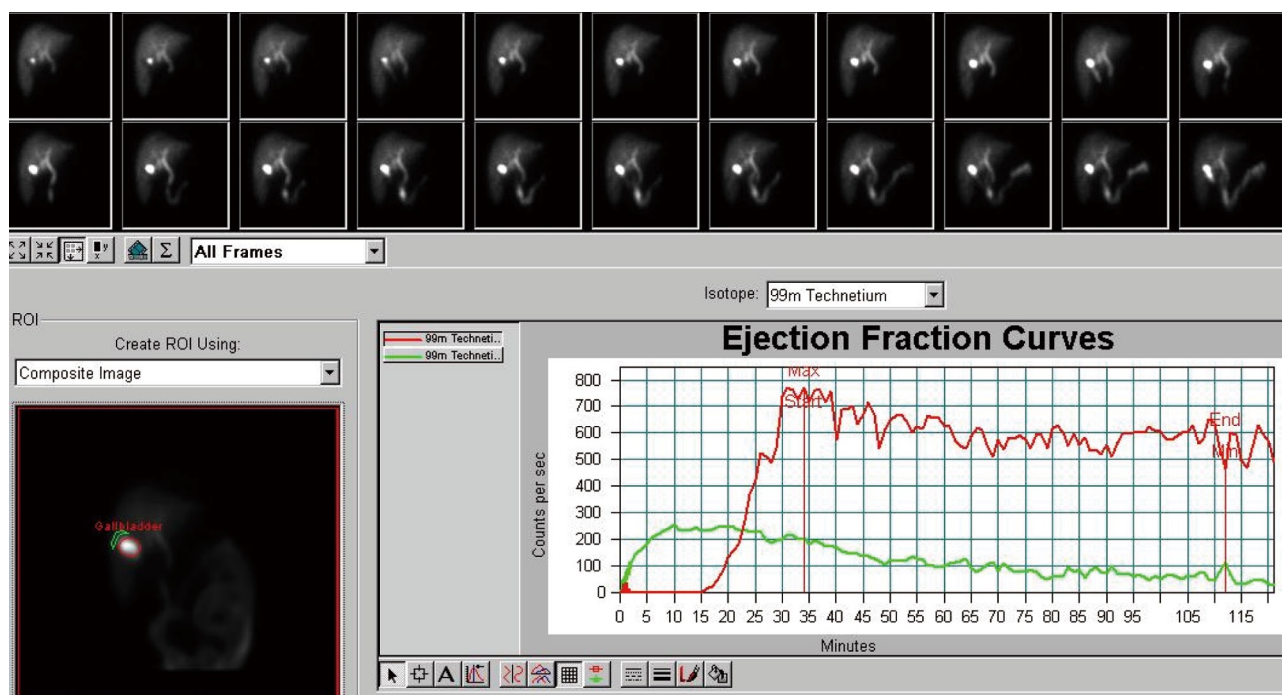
Image from Tc-99m mebrofenin cholescintigraphy and GBEF curve in a patient with asymptomatic cholelithiasis. Gallbladder emptying was slower and was not completed during the study.
